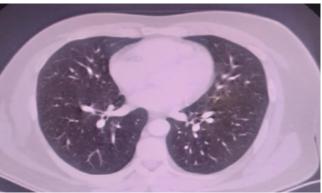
Preoperative contrast-enhanced upper and lower abdomen computed tomography (CT) imaging, revealing the lung parenchyma in the examination area to be within normal limits
